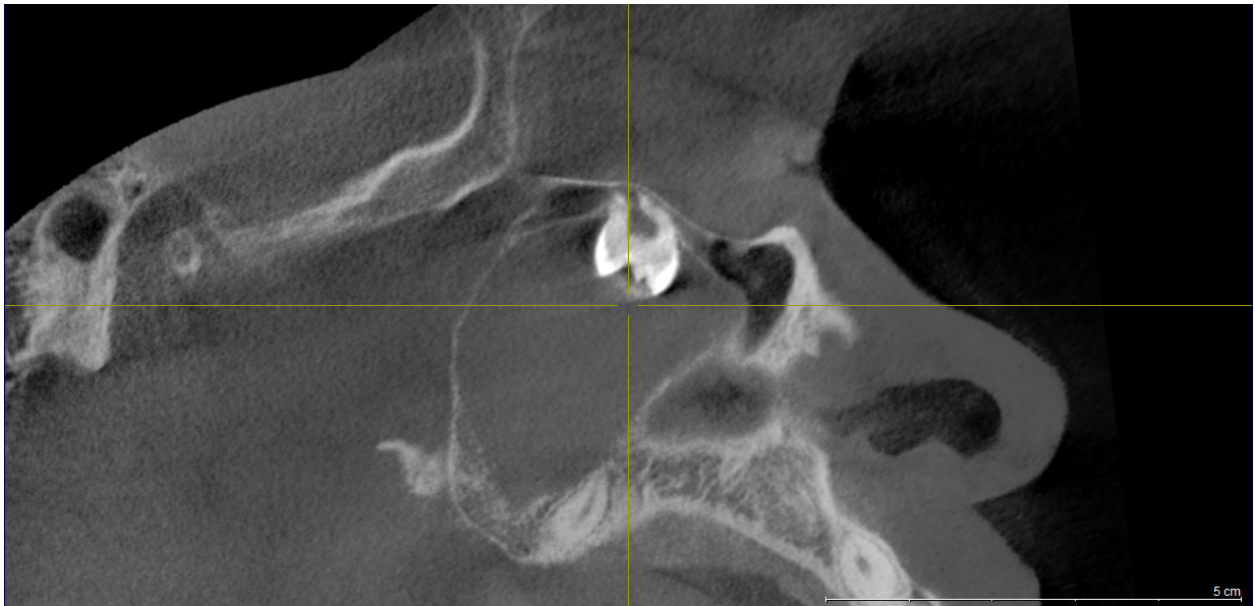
CBCT scan of an OKC with the appearance of daughter cysts
